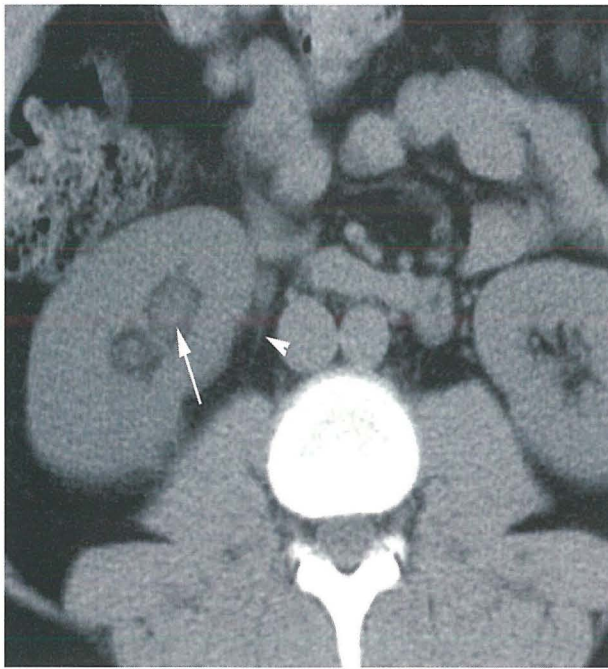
Protease inhibitor deposition in a 35-year-old man with HIV disease taking indinavir who presented with right flank pain radiating to the right groin. (a) Axial CT scan of the kidneys shows dilatation of the right renal collecting system (arrow) and mild stranding of the perinephric fat (arrow head) medial to the lower pole of the right kidney. (b) A more inferior image shows dilatation of the right ureter (arrow). (c) Another more inferior scan shows that the right ureter remains dilated to the ureterovesical junction (arrow). No calcification was identified. (d) Subsequent retrograde ureterogram shows multiple filling defects in the distal right ureter. Stricture of the ureter distal to the indinavir fragments is likely caused by recent stone impaction near the ureterovesical junction.
